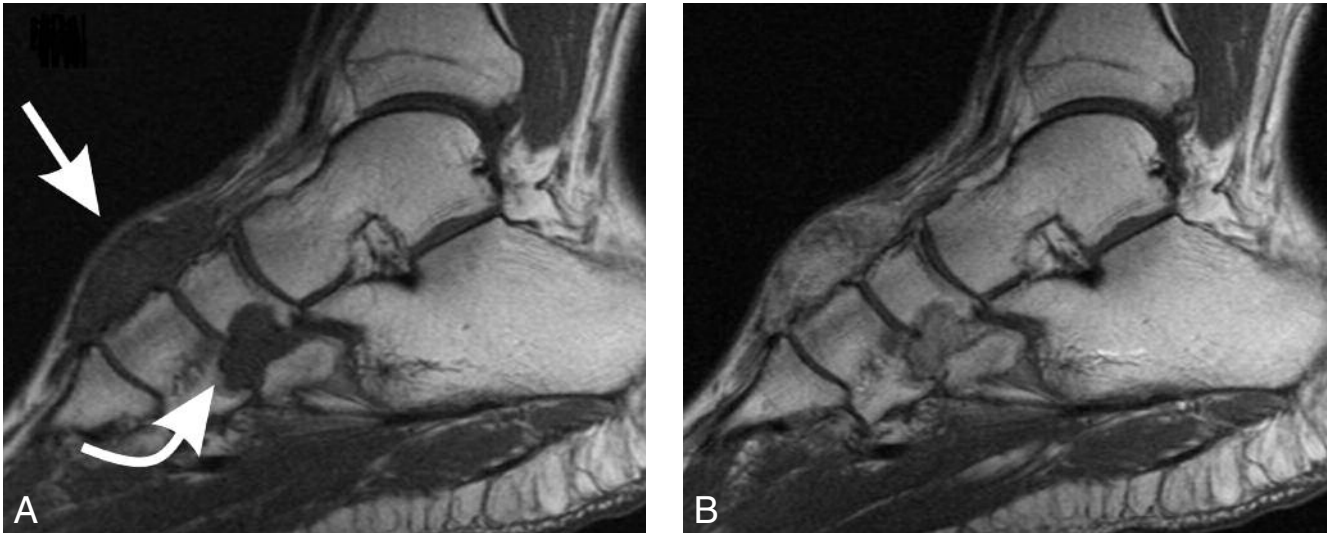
A. Sagittal T1-weighted images show a soft tissue mass at the superficial aspect of the navicular and cuneiform bones (straight arrow) with cuboidonavicular transarticular extension with bone erosions (curved arrow) and prominent heterogeneous enhancement after contrast administration (B).
